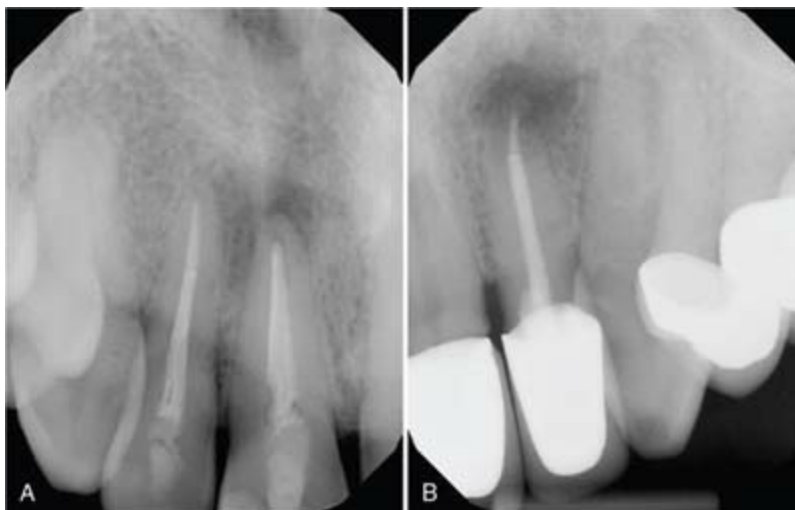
A, Well-defined radiolucency at the root apex of tooth #8. The previous root canal filling is short of the apex and exhibits numerous voids. A tissue sample obtained during apical surgery revealed a periapical granuloma. B, Well-defined radiolucency at the root apex of tooth #10. Apical surgery was completed, and the biopsy confirmed a periapical cyst. There is no way to differentiate periapical cysts from periapical granulomas using conventional imaging.
